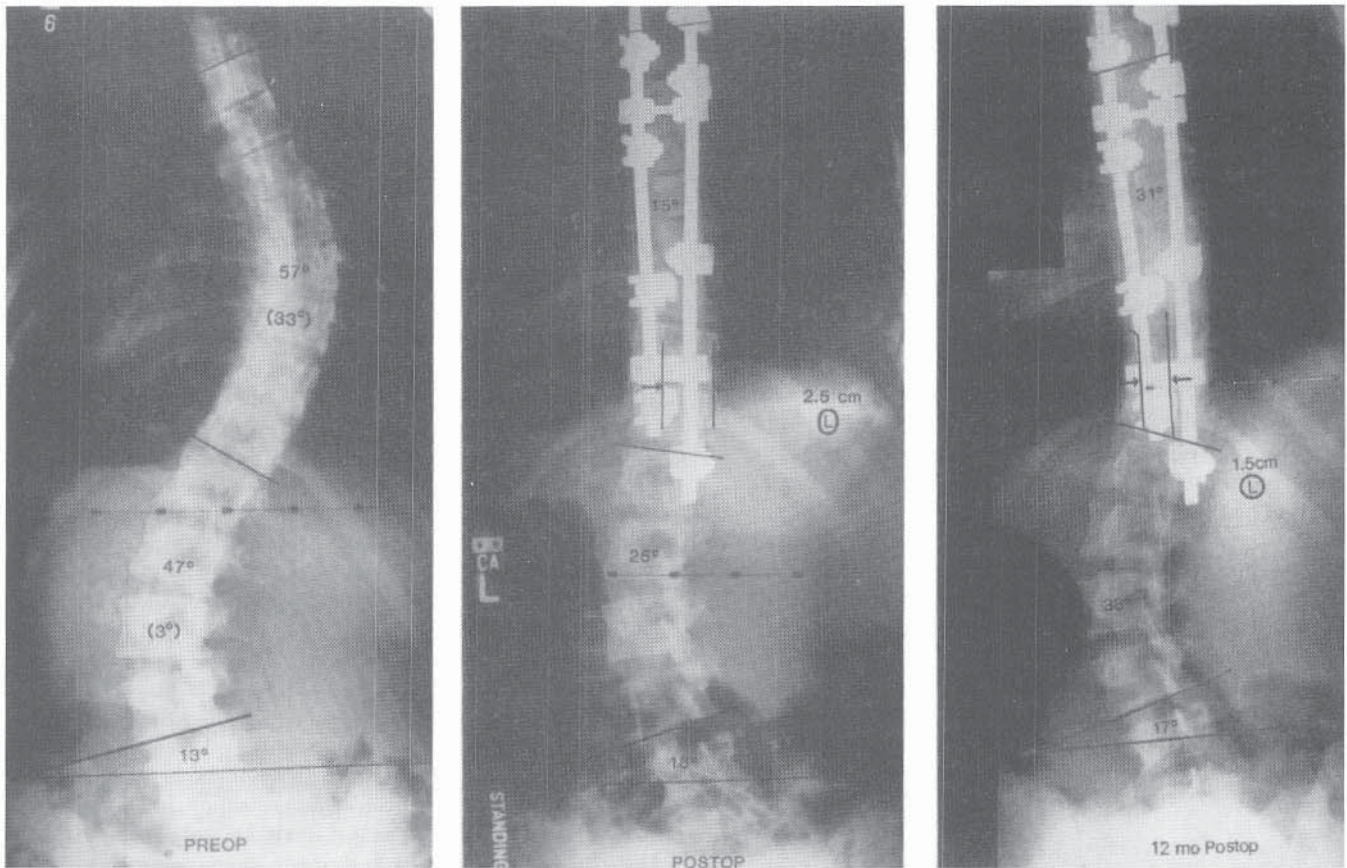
Preoperative, postoperative, and follow-up standing AP radiographs of a 17-year-old girl. *Left:* Preoperatively the lumbar curve was very flexible and the L4-pelvic obliquity measured 13 degrees. *Middle:* Postoperatively the lumbar curve remained larger than the thoracic curve, the L4-pelvic obliquity remained, and the trunk shifted 2.5 cm to the left. *Right:* At 12-month follow-up the trunk shift had improved, the lumbar curve remained larger than the thoracic curve, and the L4-pelvic obliquity persisted. (From Richards BS: Lumbar curve response in type II idiopathic scoliosis after posterior instrumentation of the thoracic curve. *Spine* 1992;17[8 Suppl]:S282-S286.)
